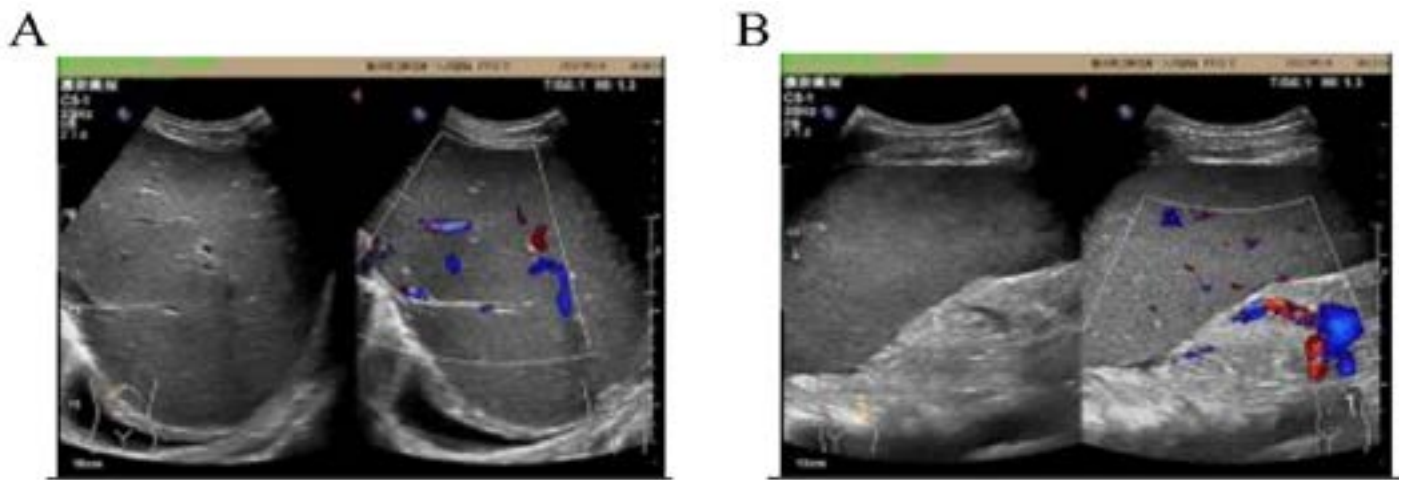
The abdominal Doppler ultrasound examination presentations on 18 May 2022 revealed enlargement of the liver and spleen, and a small amount of fluid accumulation in the thoracic cavity. A) Hepatomegaly was present, with the maximum oblique diameter of the right lobe of the liver measuring 150 mm, and the liver parenchyma showing dense and uneven echogenicity and B) Splenomegaly was present, with a longitudinal diameter of 142 mm and a thickness diameter of 47 mm, and the spleen showing uneven echogenicity.
